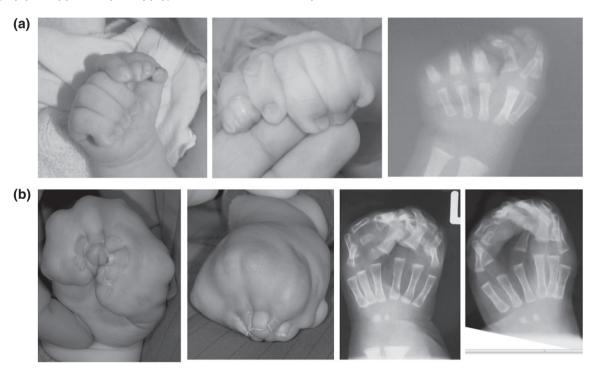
Families 1 and 2 with clinical signs of Haas-type polysyndactyly. (a) Family 1 is a non-consanguineous family from Peru. The affected boy showed a polysyndactyly of the both hands including pre-axial and post-axial polydactyly and was clinically diagnosed with a Haas-type polysyndactyly. No other abnormalities were recorded. The radiograph shows the left hand of the affected boy. (b) In family 2 father and son presented with complete cup shaped polysyndactyly of the hands including bilateral hexadactyly. The feet showed partial syndactyly of toes III–IV and complete syndactyly of IV-V. Pictures and radiographs show hands of the affected son.
